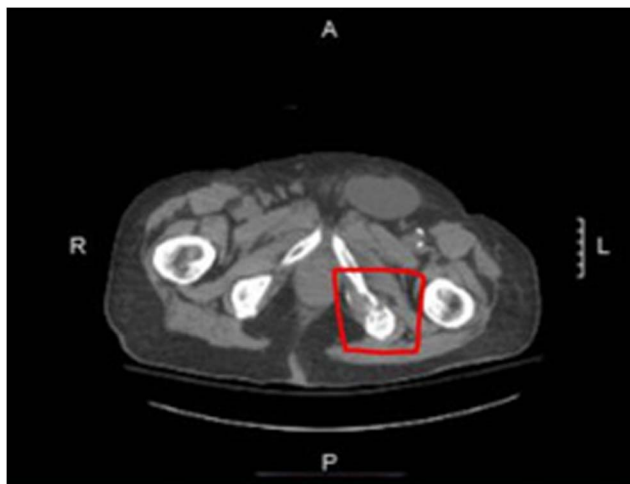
Left posterior inferior pubic rami lytic lesion—CT.
